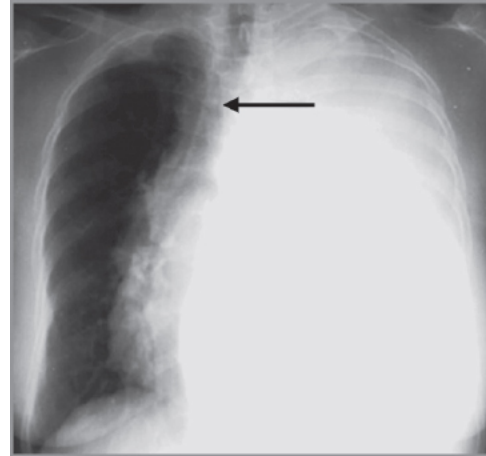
Chest X-ray PA view showing homogeneous opacity on the left hemithorax with trachea shifted to opposite side suggestive of left-sided massive pleural effusion (arrow).
